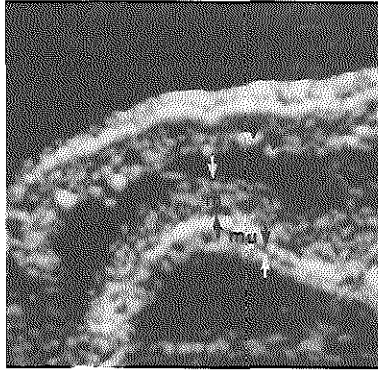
B. Longitudinal *in vitro* ultrasound image of canine small intestine following venous thrombosis; arrows indicate mucosa (m) and muscularis (mu) layer respectively (surrounded by saline) Arrowhead: mucosal air.
